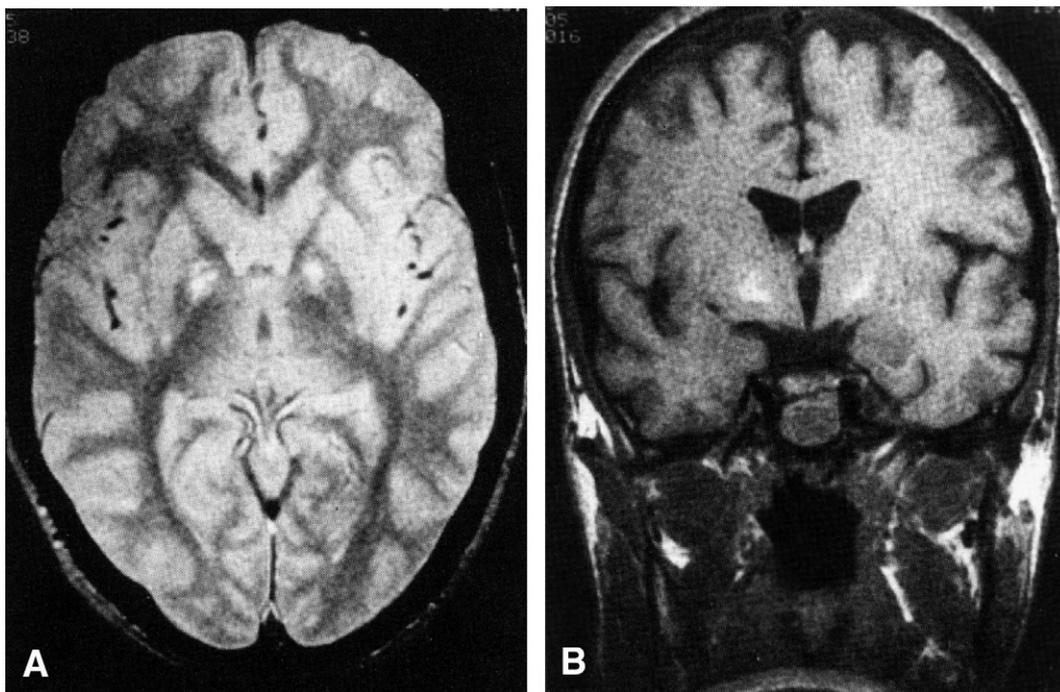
(A) Proton density brain MRI, transaxial view, shows bilateral hemorrhage in the globus pallidus. (B) T1-weighted brain MRI, coronal view from Tom et al. [21].
